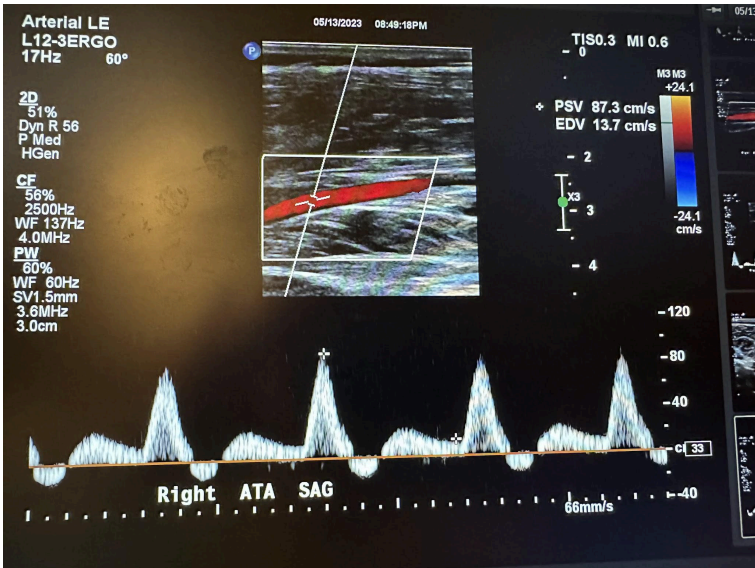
Sagittal image of the right anterior tibial artery with color Doppler and waveform analysis.
